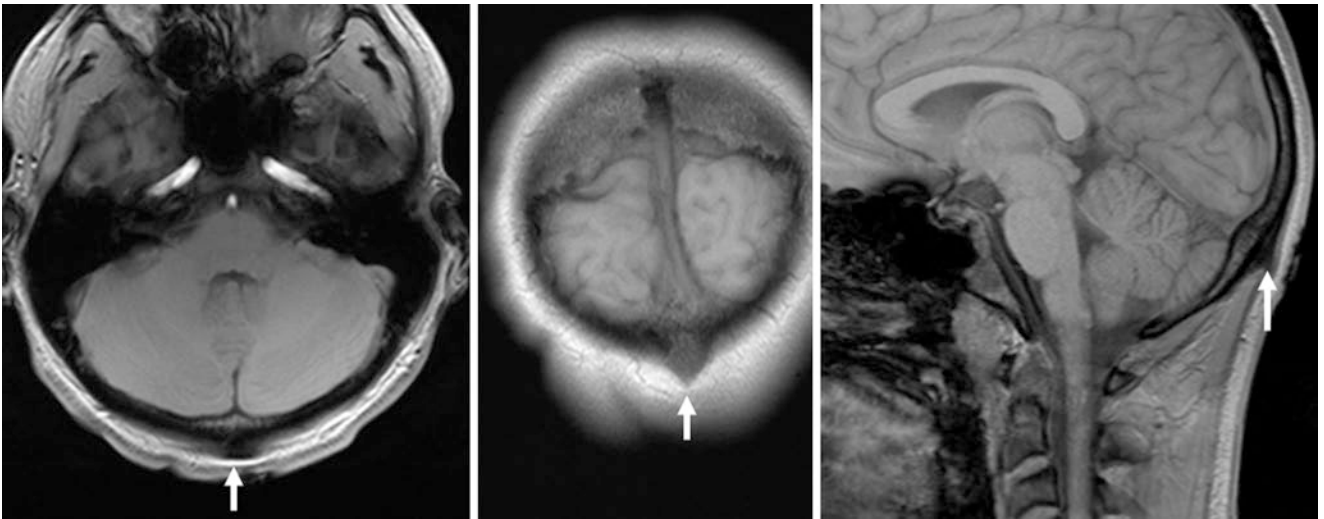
A 16 year old; the patient's mother felt a skull mass that was found to be a prominent EOP (*arrows*) on 1.5T noncontrast gradient echo T1WI MRI in the axial (*left*), coronal (*middle*), and sagittal (*right*) planes
